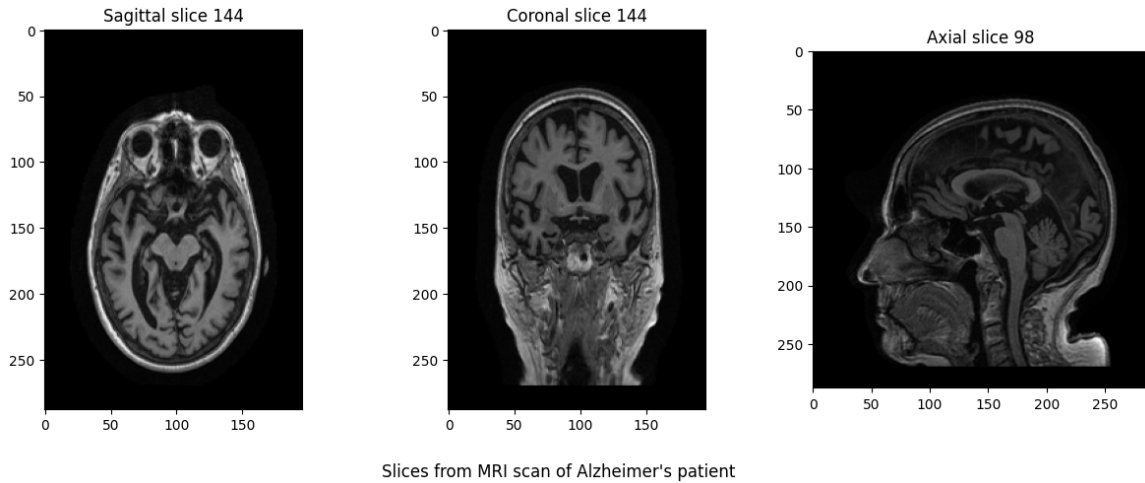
Middle sagittal, coronal and axial slices of Alzheimer's patient from MRI scan
